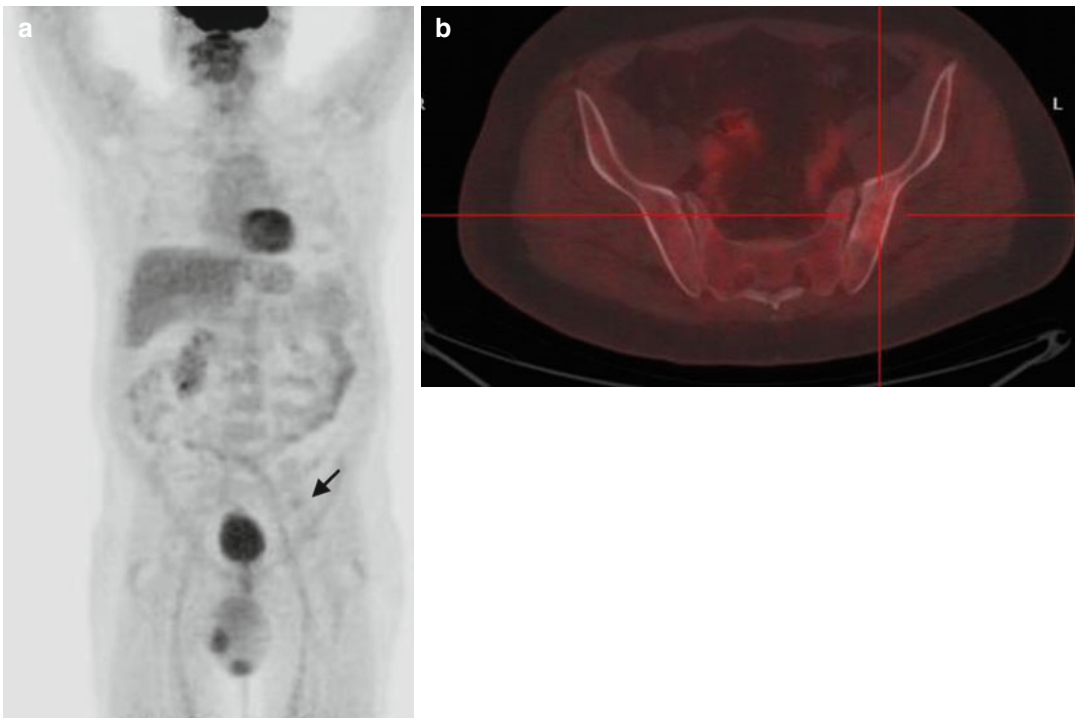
(a, b) MIP-PET and fused PET/CT – end of treatment: Mild 18FDG uptake at the *left* iliac bone, lower than that of the mediastinum (*black arrow* in the MIP image)
